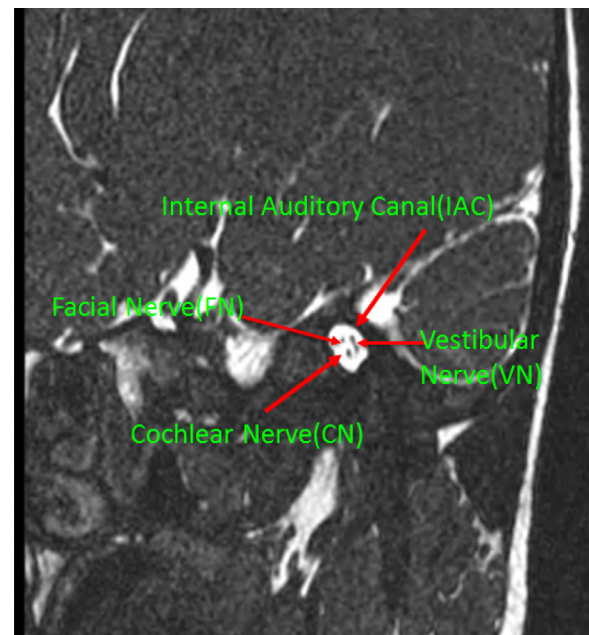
The oblique sagittal 3D-CISS MR image showing CN.
